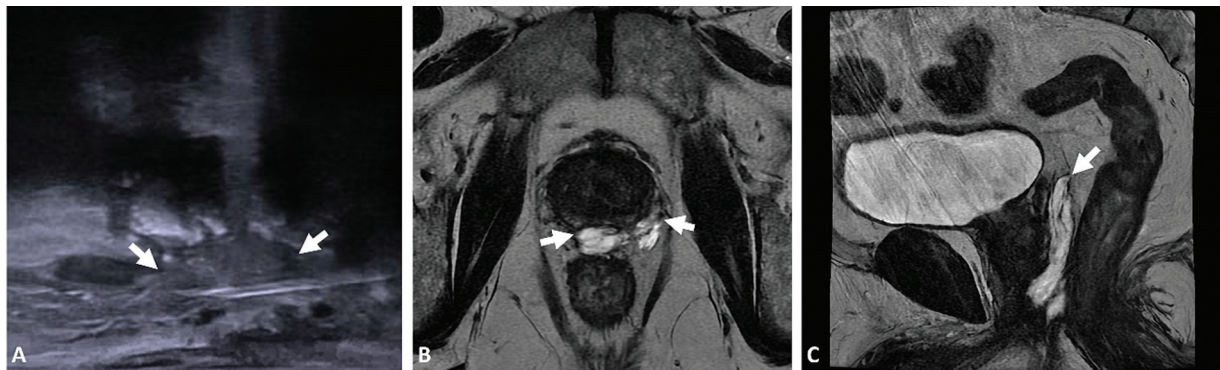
SpaceOAR. (A) Transrectal ultrasound in axial view showing transperineal injection of hydrogel (SpaceOAR). (B) Axial and (C) sagittal T2-weighted images showing rectoprostatic separation due to hydrogel injection (*arrows*).
